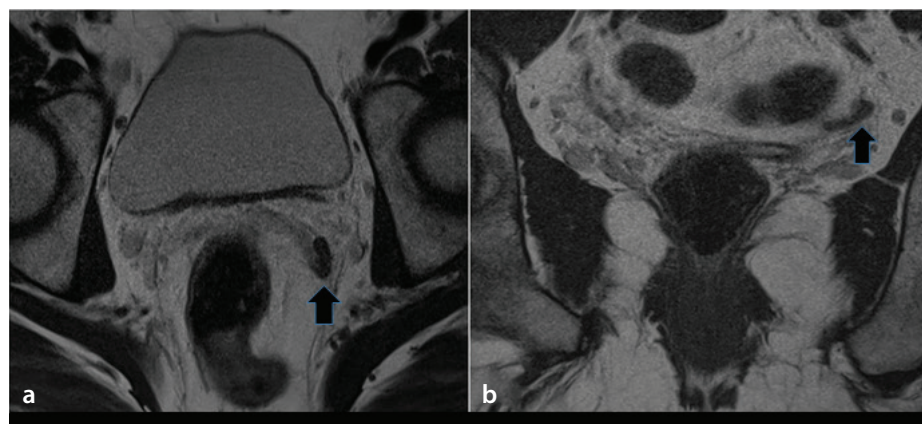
A 24-year-old patient with bilateral vasal agenesis and azoospermia. The T2-weighted axial (a) and coronal (b) images show the intra-abdominal part of the left vas deferens (black arrows).
